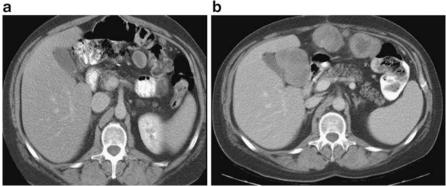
CT and PET showing progression in response to imatinib (exon 9 KIT mutation), (a and b) CT before therapy and 2 months after starting therapy
